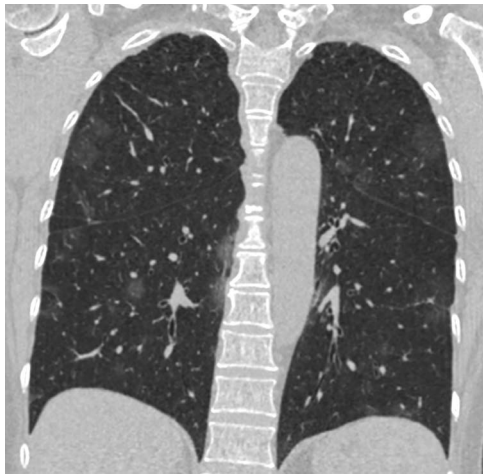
The HRCT scan of a 59-year-old female patient with multiple-lobe involvement of ground-glass opacity (GGO). There was a periphery distribution of GGO at the right and left upper lobes and a random distribution at the right and left lower lobes.
